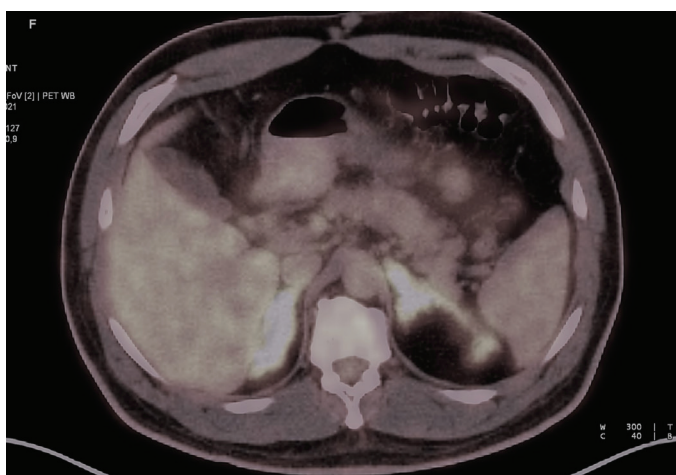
18F-FDG PET/CT image of congenital adrenal hyperplasia
